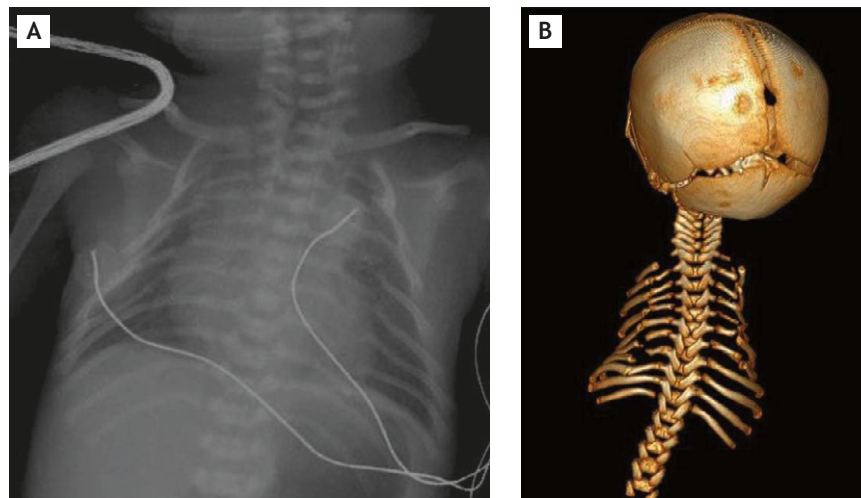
(A) Chest radiograph and (B) three-dimensional computed tomography showed multiple posterior rib-gap defects with flail chest and a bell-shaped thoracic cage.
